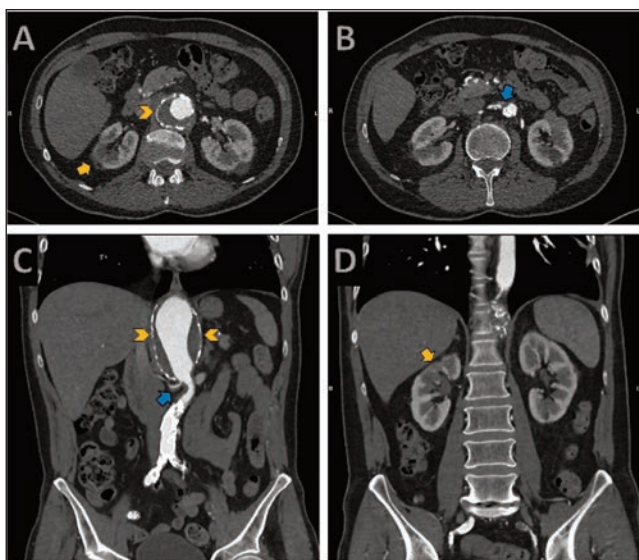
CT Angiogram: Axial (A and B) and coronal (C and D) CT images showed right upper renal pole hypodensity, lack of enhancement, and renal cortical loss in the right renal upper lobe keeping with an old infarction (yellow arrows in images A and D), as well as a suprarenal abdominal aortic aneurysm reaching 6.2cm with mural thrombus formation (yellow arrowheads in images A and C), occluded coeliac artery, occluded left iliac artery and severe calcified stenosis at the origin of the right renal artery (blue arrows in images B and C).
